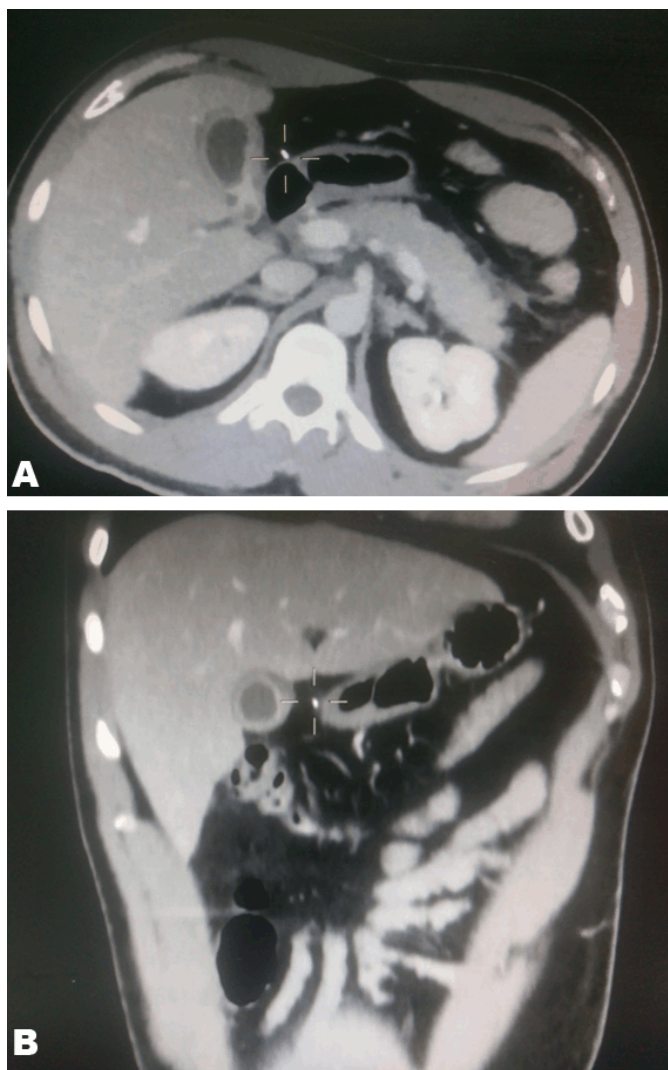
(A, B) Foreign body showing on computed tomography scan.
